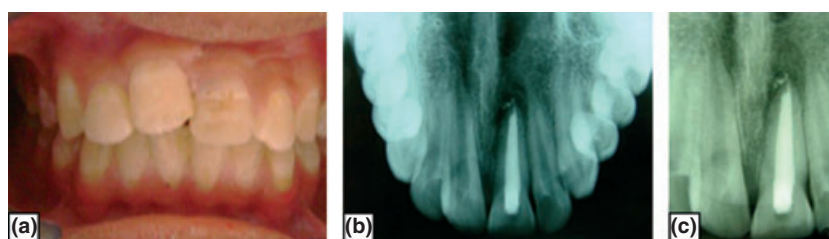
(a) Posttreatment intraoral photograph showing the erupted right central incisor. (b) and (c) Posttreatment occlusal and periapical radiographs after 12 months demonstrating apical healing.
